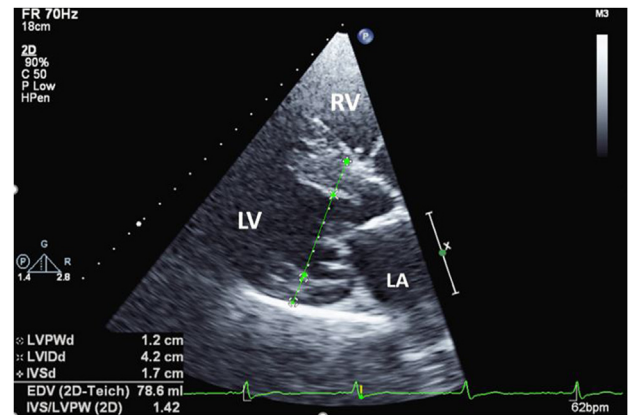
Case 1: two-dimensional TTE, parasternal long-axis diastolic view, demonstrates HCM with asymmetric left ventricular septal hypertrophy. LA, Left atrium; LV, left ventricle; RV, right ventricle.
